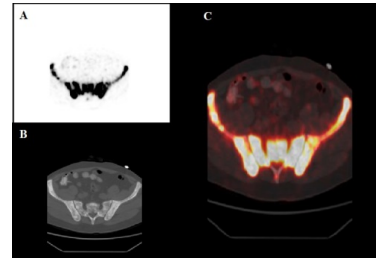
Axial pelvis PET, CT and Fusion images.
